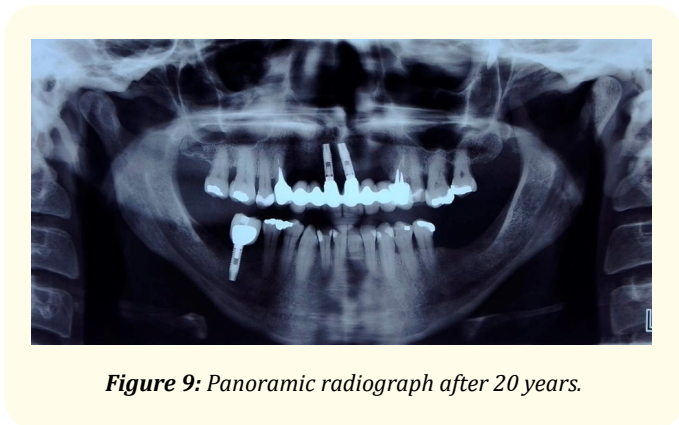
Panoramic radiograph after 20 years.
